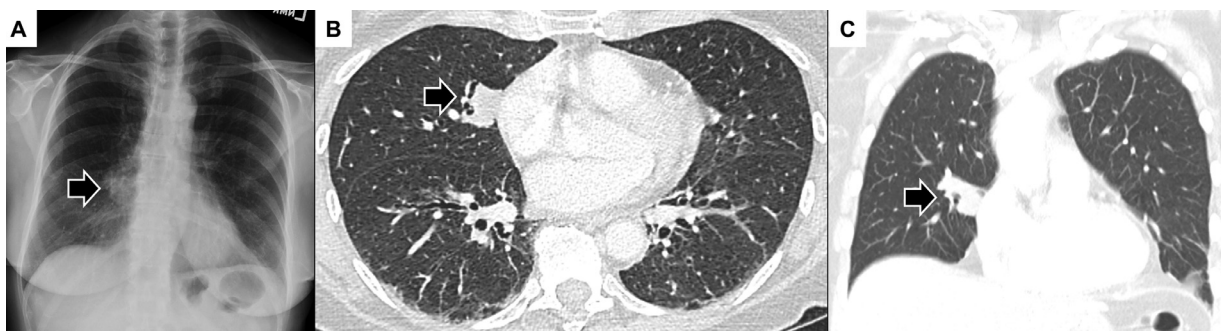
Imaging findings in a 69-year-old woman with pulmonary light chain deposition disease (case 3). (A) Chest radiograph reveals a round opacity at the central right midlung (arrow). Axial (B) and coronal (C) contrast-enhanced chest CT slices demonstrate a 2.0 x 2.0 x 1.3 cm pulmonary nodule in the medial segment right middle lobe (arrow).
